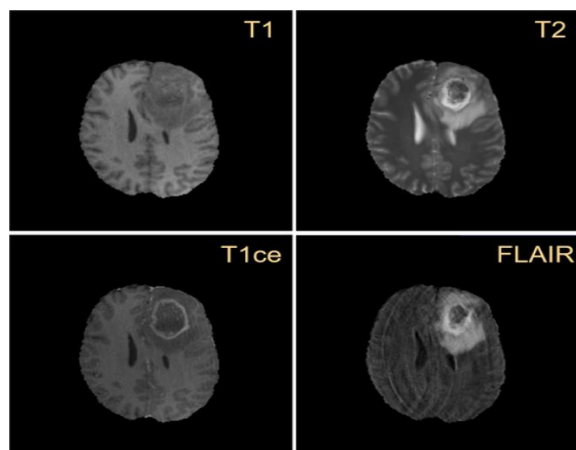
Multimodal MRI sequences for brain tumor
